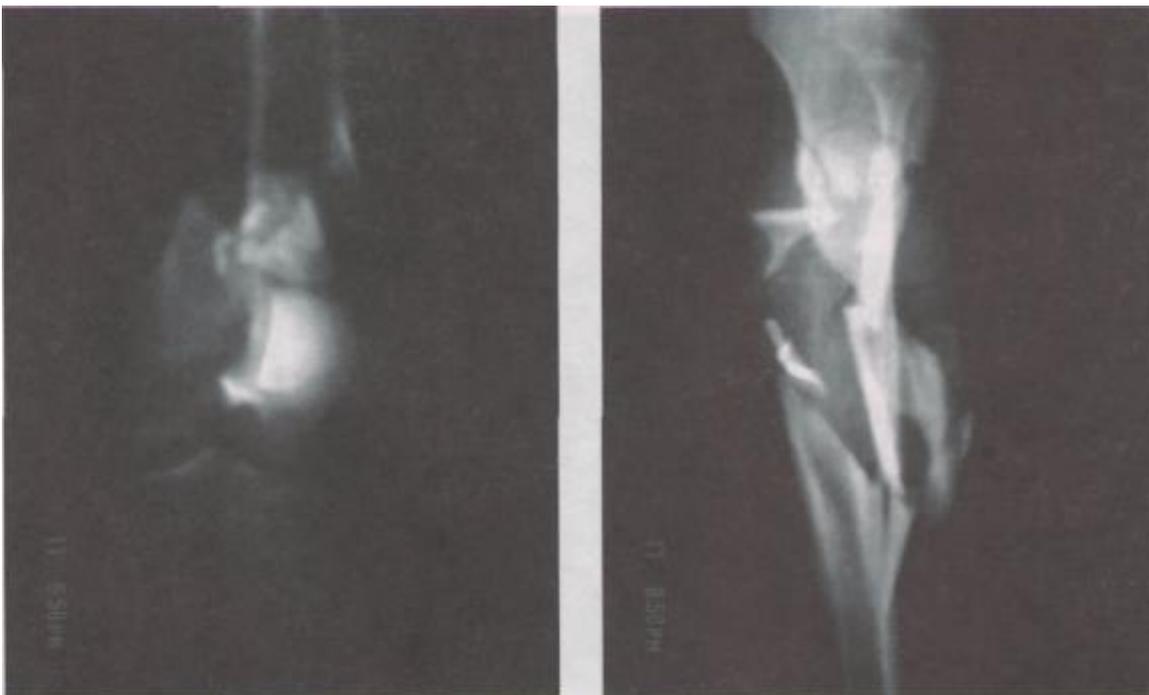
X-ray of the tibia of patient A. Comminuted fracture of the tibia
